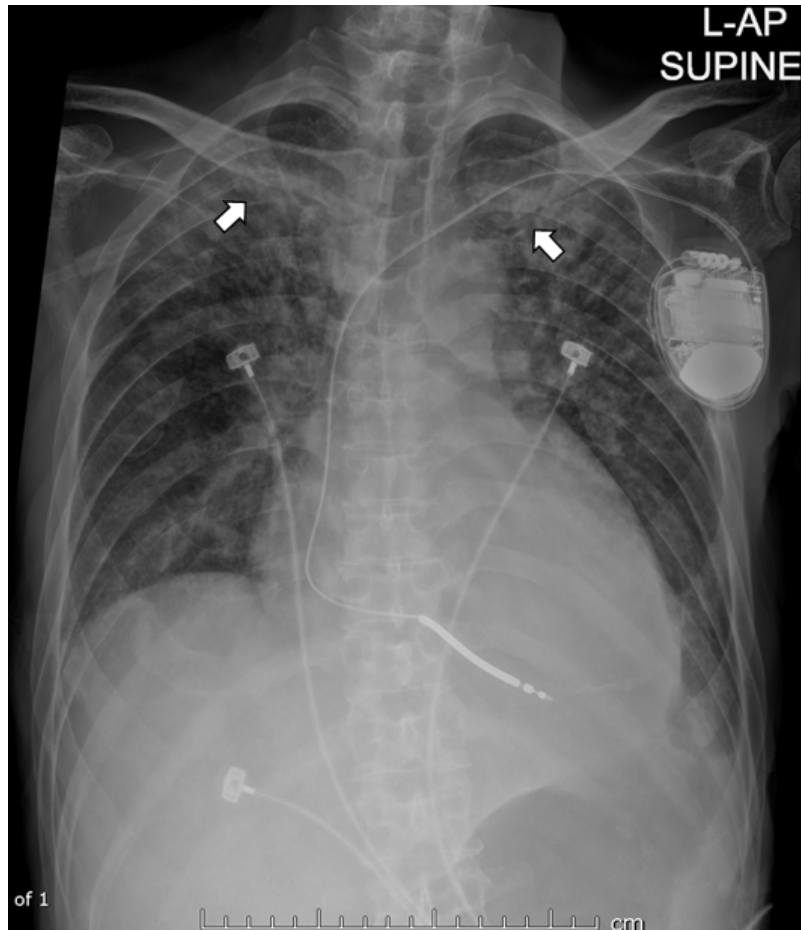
AP supine portable chest radiograph reveals diffuse patchy opacification with air bronchogram (white arrows) in both lungs, predominantly in both upper lobes.
